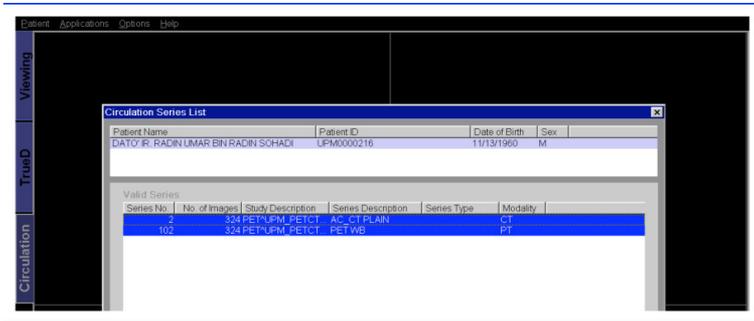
Select the two row of studies containing CT and PT which appear on the screen
